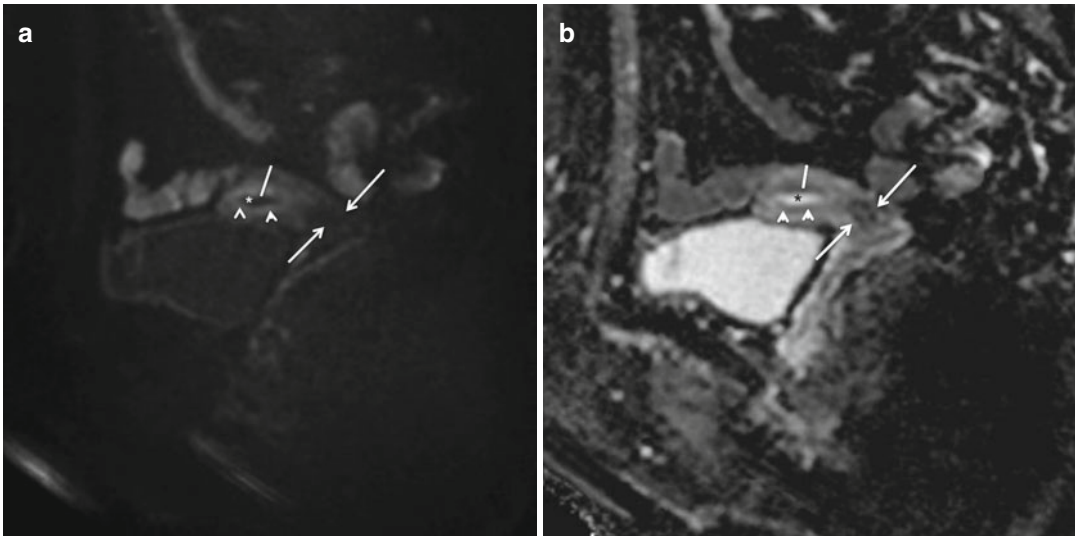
(a, b) Uterine anatomy on diffusion-weighted imaging. Sagittal diffusion-weighted image (DWI) (TR/TE 3,100/98 ms, $b=1,000$ s/mm²) (a) and corresponding apparent diffusion coefficient (ADC) map (b) are displayed. Endometrium (*star*) appears hypointense on DWI and hyperintense on ADC, compared to the myometrium
